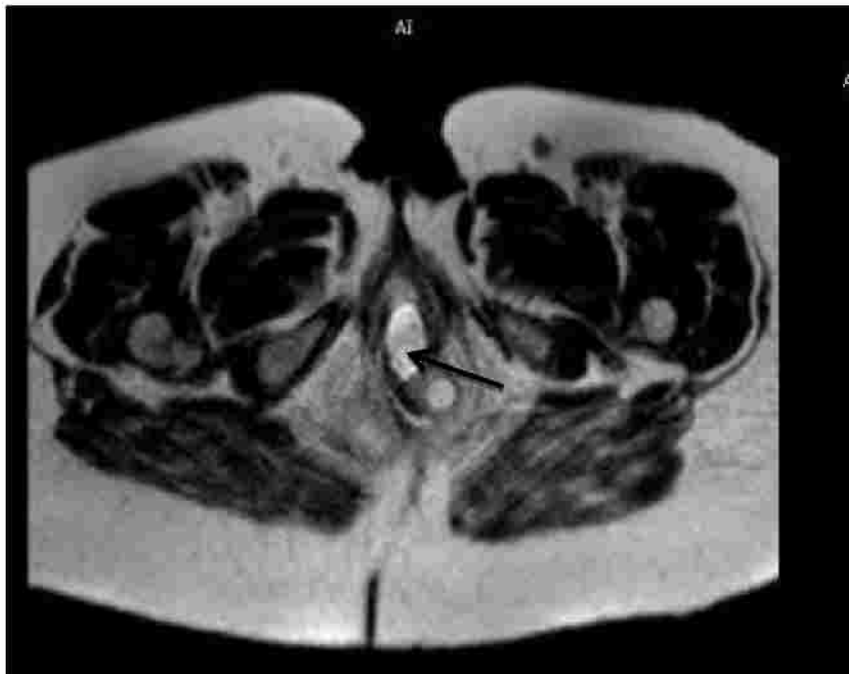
Axial T2-weighted image of the same patient showing the bladder protruding through perineal hiatus.
